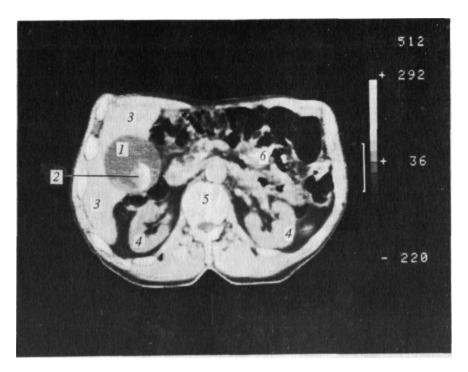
CT scan of a patient with cholelithiasis.
